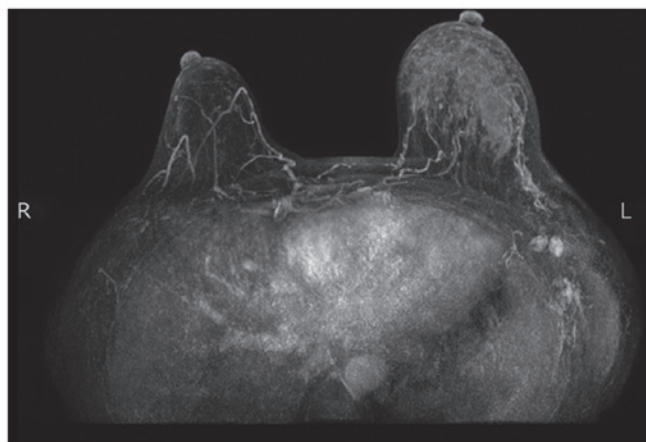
Enhanced magnetic resonance imaging suggesting inflammation or inflammatory breast cancer due to the heterogeneous architectural distortion and skin thickening (Breast Imaging Reporting and Data System type 4).
